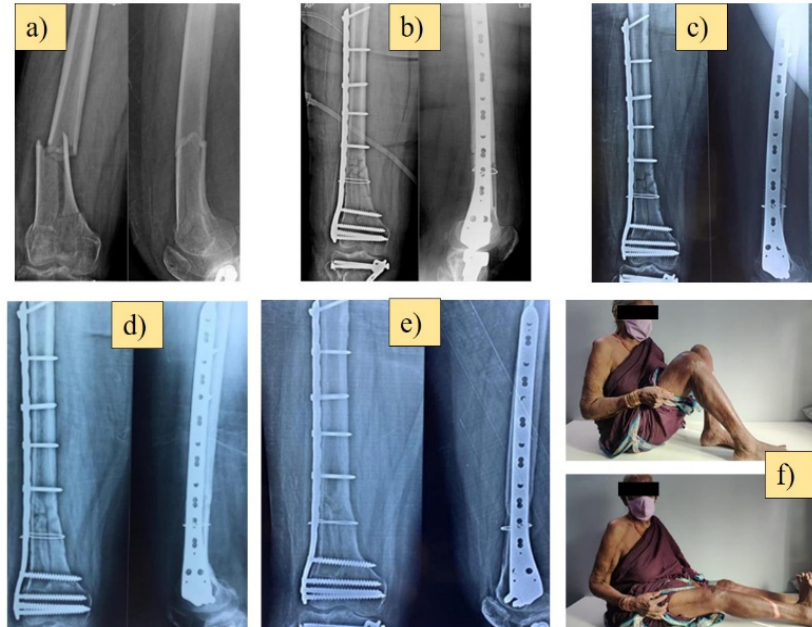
a) Pre operative x ray showing distal femur fracture b) Post operative x-ray showing well attained reduction through LCP . At follow ups serial x ray images were taken c) at one month d) 3 months and e) 10 months post surgery. Clinical evaluation of active range of knee flexion and extension at the end of follow up period.
